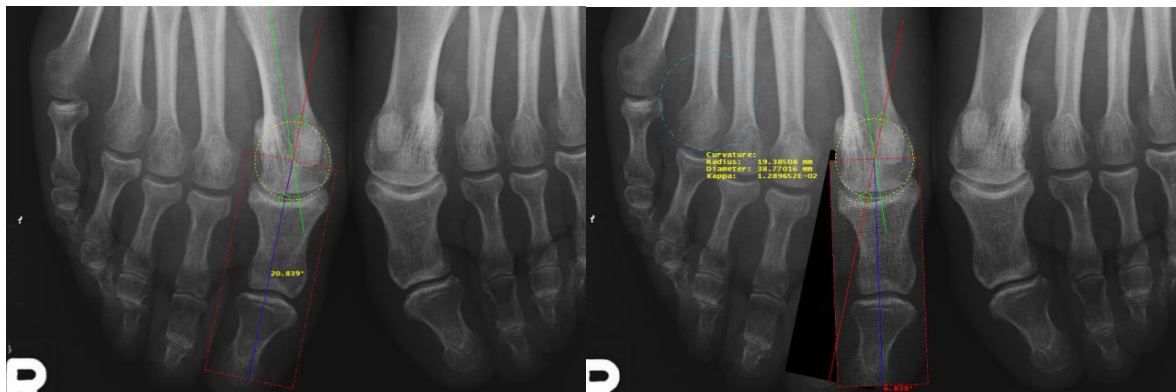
Preoperative measurements conducted over x-ray images.
